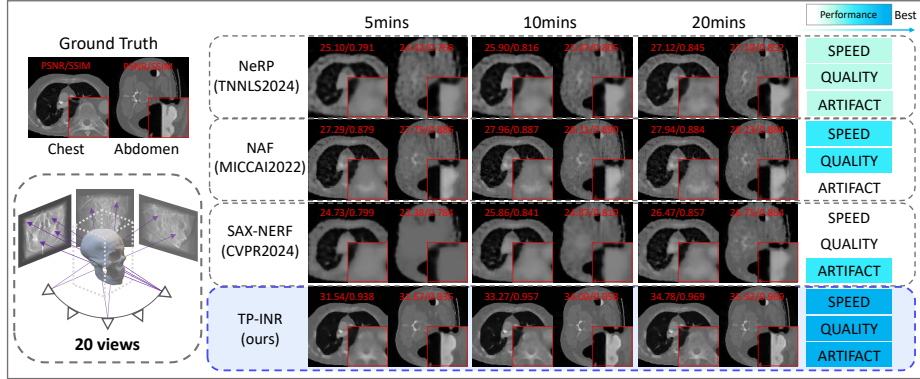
Sparse-view 3D CT reconstruction with the state-of-the-art methods. Comparisons using NeRP [17], NAF [24], and SAX-NeRF [2] highlights our superior performance in learning efficiency, reconstruction precision, and artifact removal.
